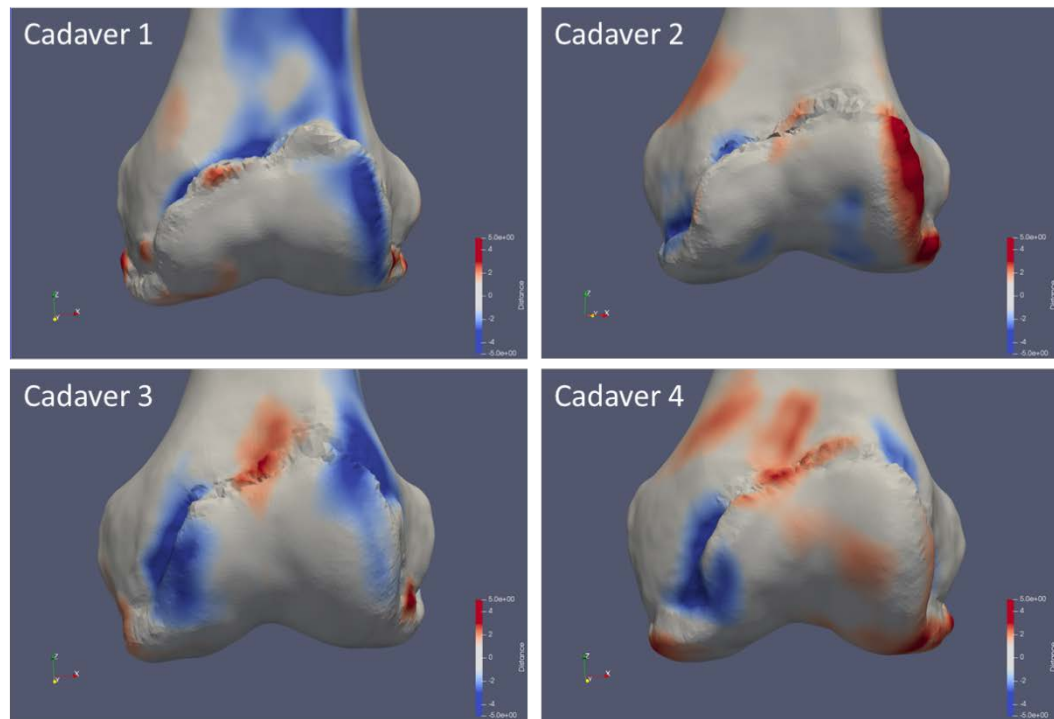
Differences in XR and CT segmentations. Oversegmentation greater than 3 mm is shown in dark red and undersegmentation greater than 3 mm is shown in dark blue, with a gradient in between. Segmentation errors less than 1 mm are shown in white.
